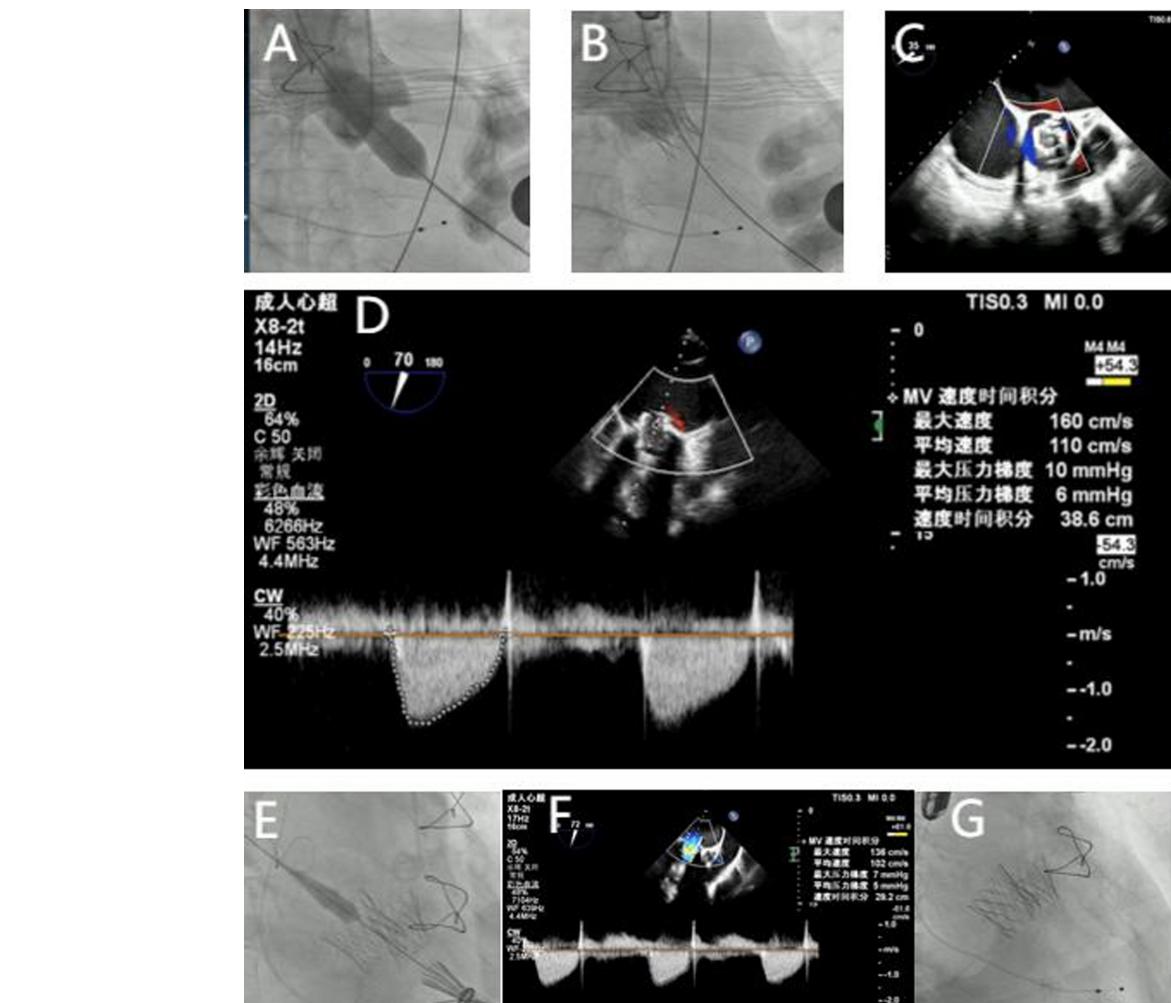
Transapical aortic and mitral ViV procedure using ScienCrown. A: An 18-mm balloon aortic valvuloplasty pre-dilation. B: Successful 21mm ScienCrown deployment demonstrating absence of paravalvular leak. C: Post-implantation transesophageal echocardiography (TEE) confirming no perivalvular leakage. D: Post-procedural TEE documenting mean aortic gradient of 6 mmHg. E: Optimal 25 mm ScienCrown placement in mitral position. F: Post-deployment TEE assessment showing a mean mitral gradient of 5 mm Hg. G: Postoperative imaging demonstrating appropriate spatial orientation and stent expansion for both implanted valves.
